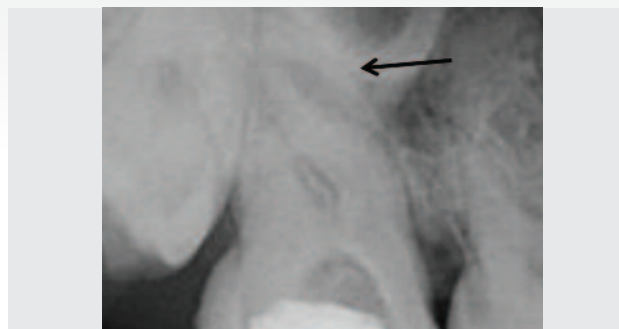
Pre-operative radiograph revealing challenging root canal morphology and an apical radiolucency on the apex of the mesial root
